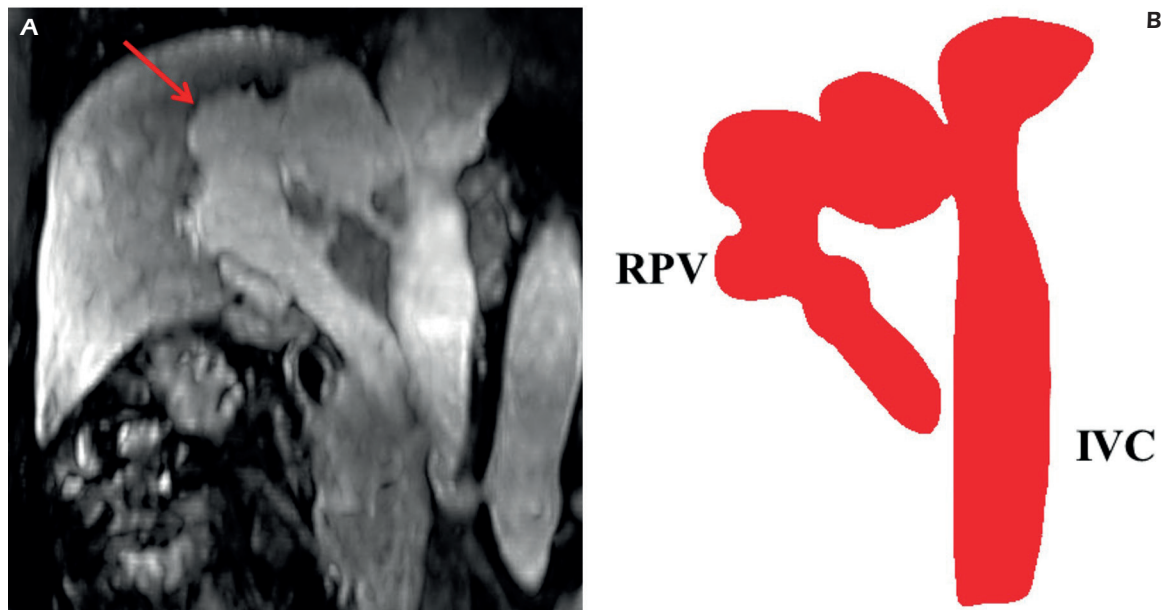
Congenital intrahepatic portosystemic shunts - type 1. A, Contrast-enhanced MRI – coronal MIP reconstruction. A single large vessel (*arrow*) runs from the right branch of the portal vein to the posterior surface of the liver and turns medially to enter the inferior vena cava just below the insertions of the hepatic veins. B, RPV: right portal vein; IVC: inferior vena cava.
